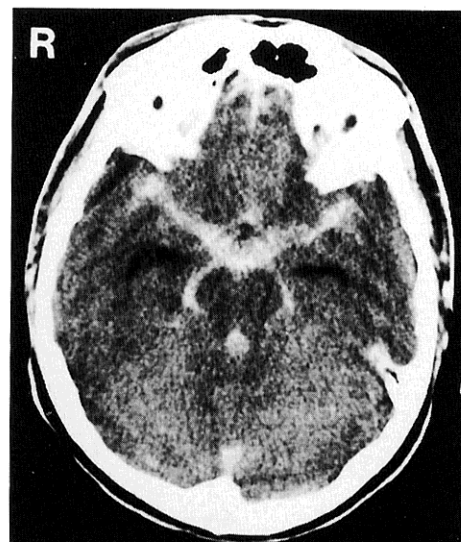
Computed tomography scan on admission showing subarachnoid hemorrhage at the base of the brain.
